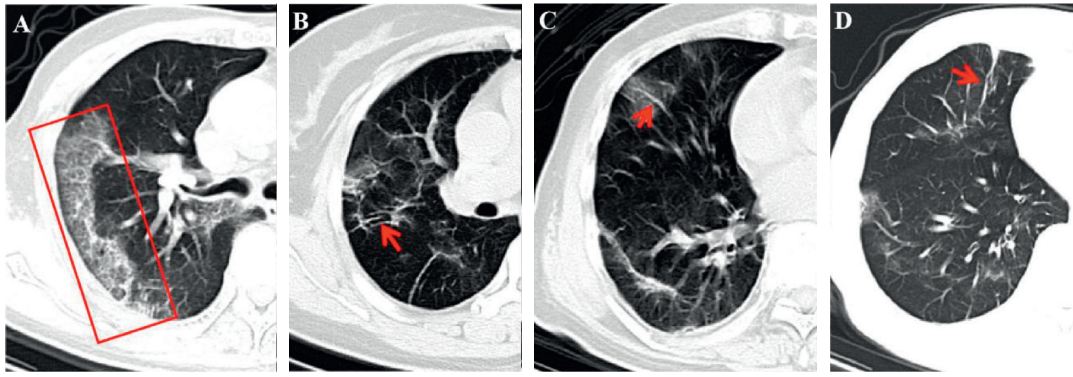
(a) A 79-year-old male COVID-19 patient with prolonged fever for 10 days. The CT displays the reticular pattern in the right upper lobe (red rectangle) (5 days after the onset of initial symptoms). (b) A 40-year-old female confirmed patient with running nose and whole-body pain for 11 days. The bronchial wall thickening is demonstrated on the follow-up CT (20 days after initial symptoms onset) (red arrow). (c) A 79-year-old male COVID-19 patient with prolonged fever for 10 days. The CT displays the vascular enlargement through the lesion in the right middle lobe (red arrow) (4 days after the onset of initial symptoms). (d) The same patient in (c) and the fibrosis is left after treatment for 10 days (red arrow).
